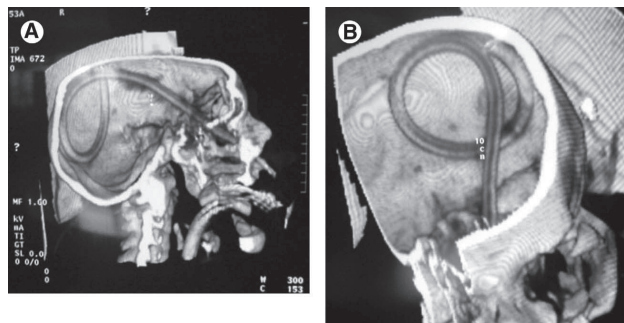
(A, B) Computed tomography (superficial 3-dimensional reconstruction) showing the intracranial course trajectory of nasogastric tube. *Genu et al. Inadvertent Intracranial Placement of an NG Tube. J Oral Maxillofac Surg 2004.*
